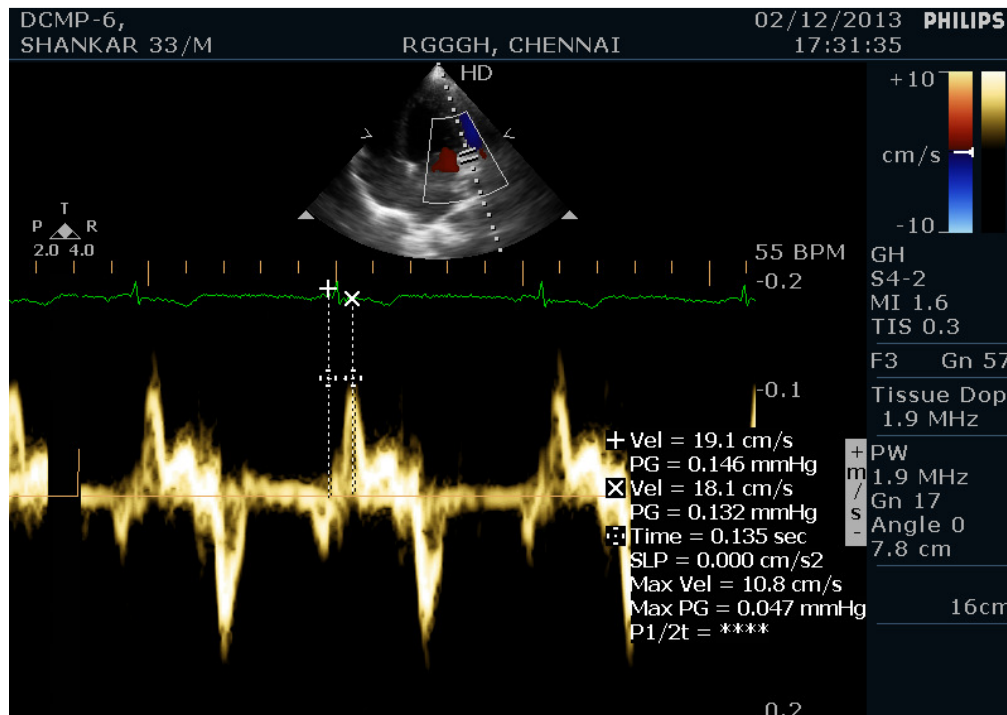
Measurement of Ts of basal anterolateral wall in apical 4 chamber view using tissue Doppler imaging.
